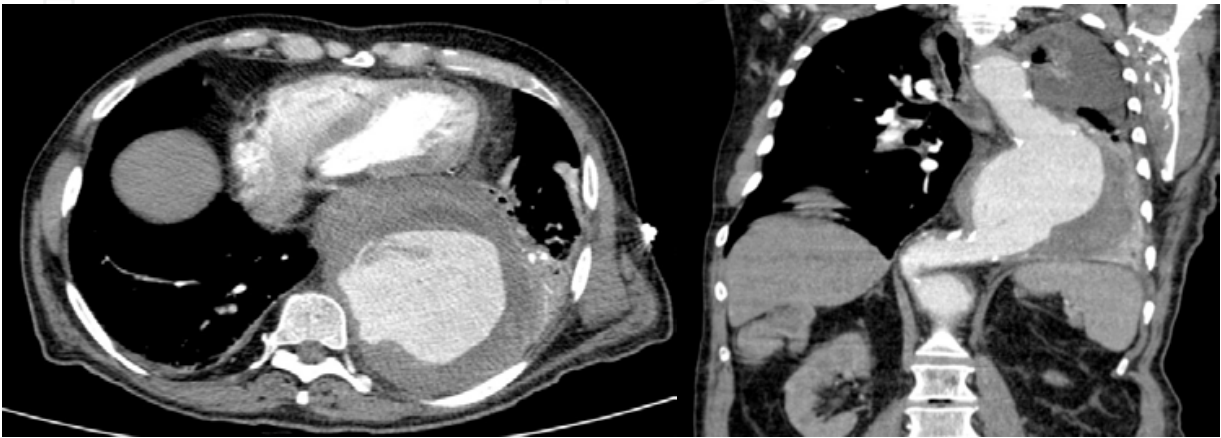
Case 23. Upper: Chest computed tomography scan (transverse view) showing the thoracic aortic aneurysm measuring 10 cm in diameter. Lower: Computed tomography scan in a coronal view.
